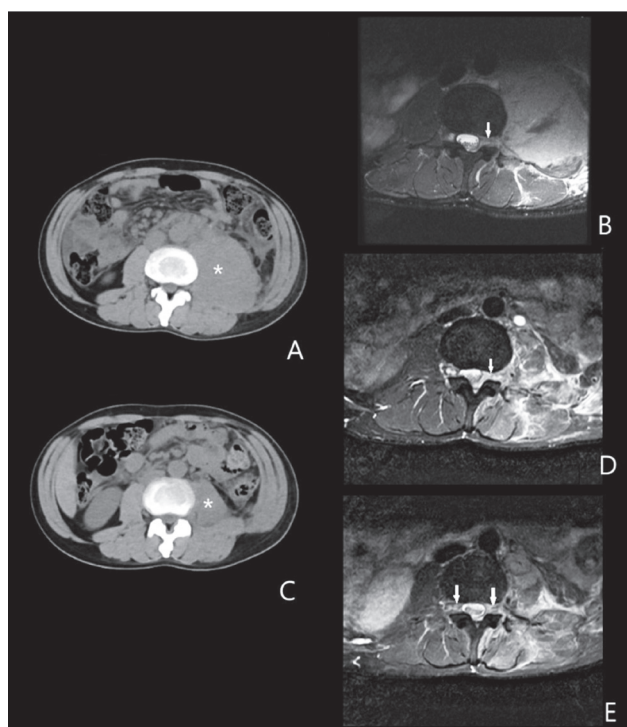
MRI revealed the progression of intraspinal involvement (arrow sign), although the resolution of the psoas tumor (star sign) was identified through abdominal CT. The tumor initially invaded the epidural space through the left intervertebral foramina; it then encased the whole spinal canal with the compression of the thecal sac and finally invaded the contralateral intervertebral foramina. All the images are at the L3 level, and all MRI sequences are T2-weighted images.
